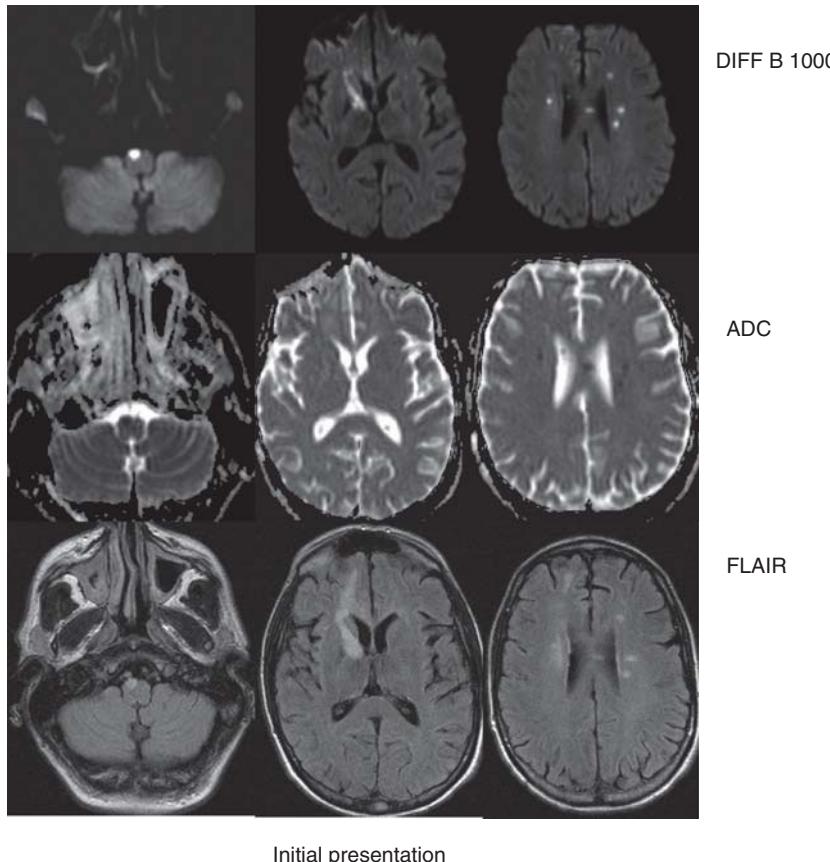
Magnetic resonance imaging shows congruent abnormalities on diffusion and T2 consistent with small penetrating end artery infarction. The image detail intensity strongly suggests a monophasic event.
